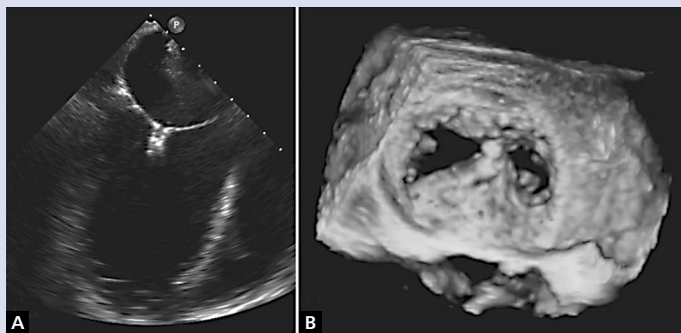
A, B. Peri-procedural echocardiographic assessment of MitraClip implantation
